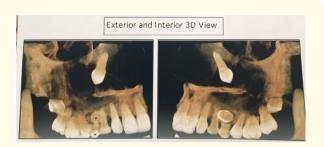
CBCT both exterior and interior 3 D view.
